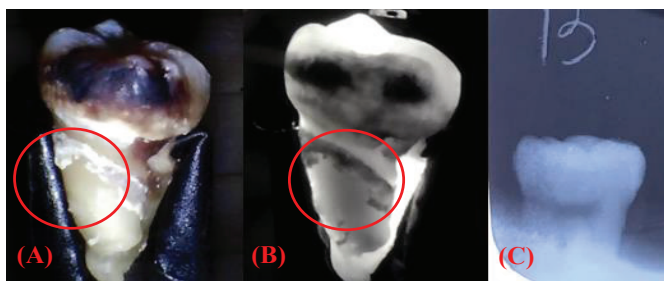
Sample 9 under visible light (A), NIR light (B), and X-rays (C).
